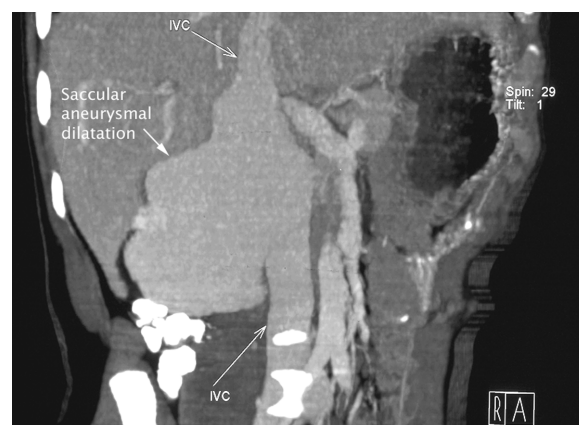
Abdominal computed tomographic angiography revealed a saccular aneurysmal dilation of the inferior caval vein.
